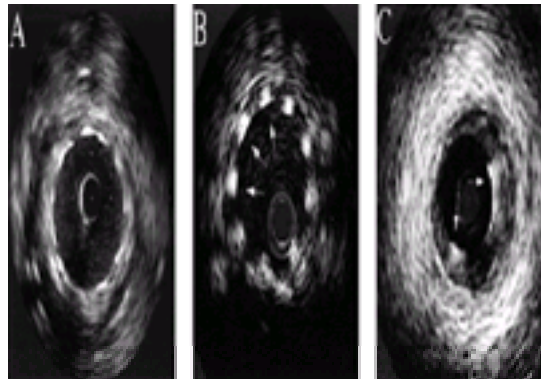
Stent signatures. A: Typical cellular design stents (Scimed NIR, Boston Scientific Scimed, Maple Grove, MN) with good apposition has an IVUS appearance where stent struts create bright echos in a radial pattern. B: The IVUS image from a self-expanding nickel-titanium design stent (Scimed Radius stent) shows the struts as discrete points (arrows). C: The IVUS image from a coil design stent (Gianturco-Roubin stent, Cook Cardiology, Bloomington, IN) displays the stent architecture as two arcs (arrows) where the ultrasound beam plane has intersected a short length of the coil.
